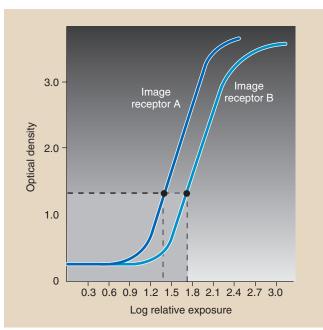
The speed of a radiographic image receptor is a relative number based on 100 as par speed.
